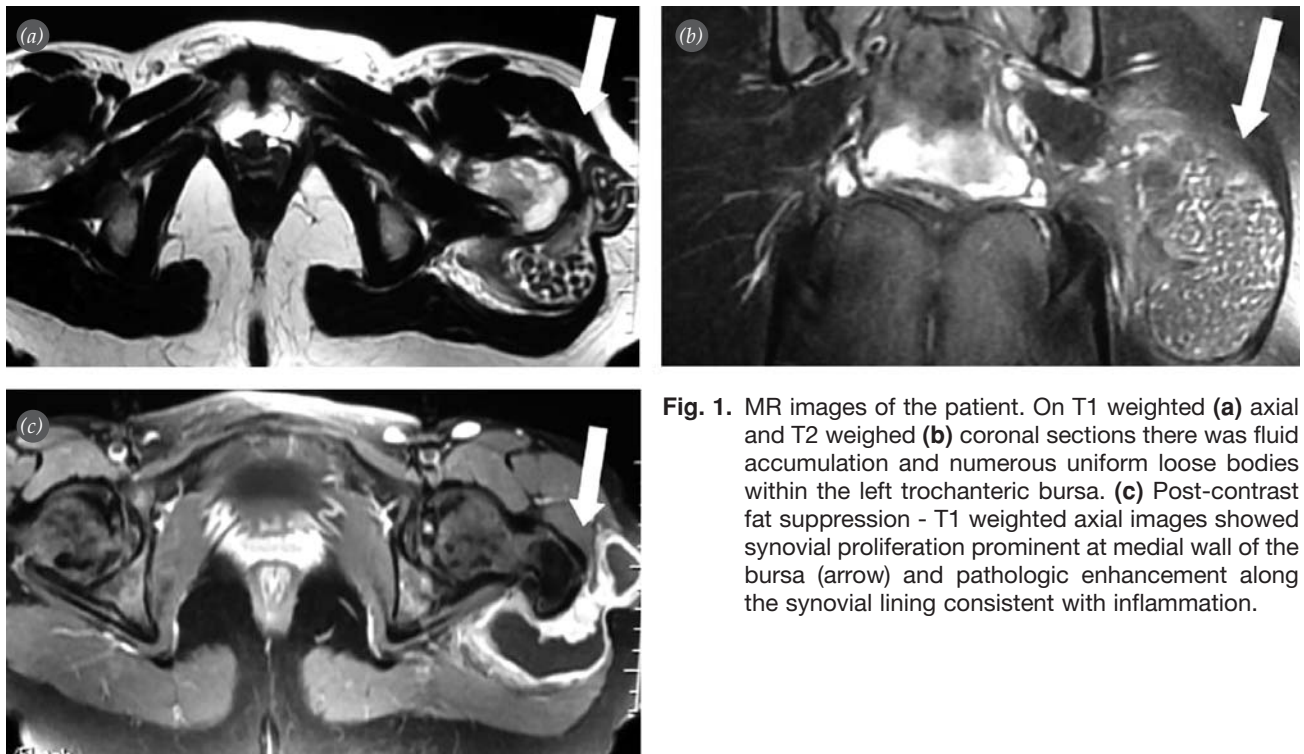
MR images of the patient. On T1 weighted (a) axial and T2 weighed (b) coronal sections there was fluid accumulation and numerous uniform loose bodies within the left trochanteric bursa. (c) Post-contrast fat suppression - T1 weighted axial images showed synovial proliferation prominent at medial wall of the bursa (arrow) and pathologic enhancement along the synovial lining consistent with inflammation.
